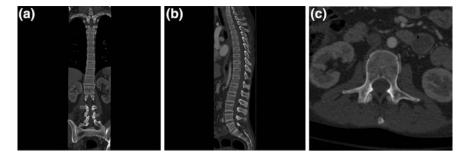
CT images of the spine in standard planar reformatting. a Coronal plane image from a CT study of the spine, with the spine partially visualized on this image, due to normal kyphotic thoracic and lordotic lumbar curvature, b sagittal plane image, and c axial plane cross section at the level of the mid-abdomen. The axial field of view is kept small in this dedicated spine imaging study to increase the in-plane spatial resolution
